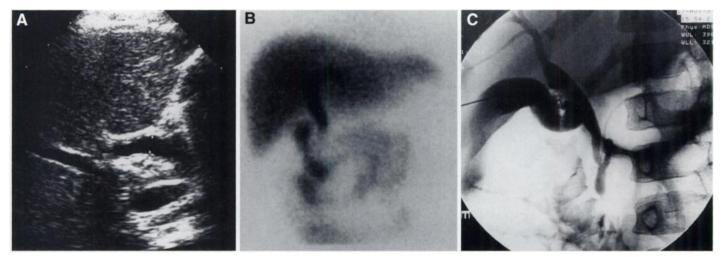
Congenital dilatation of the biliary tree (choledochal cyst). An 8-mo-old male infant presented with episodes of intermittent jaundice and abdominal pain. Ultrasound (A) reveals mild-to-moderate dilatation of the common bile duct. Hepatobiliary scintigraphy confirms (B) dilatation of the common bile duct and left hepatic duct, but no obstruction to bile flow was seen. Percutaneous cholangiogram via puncture of the gallbladder confirms the anatomical dilatation of the common bile duct and left hepatic duct (C).
